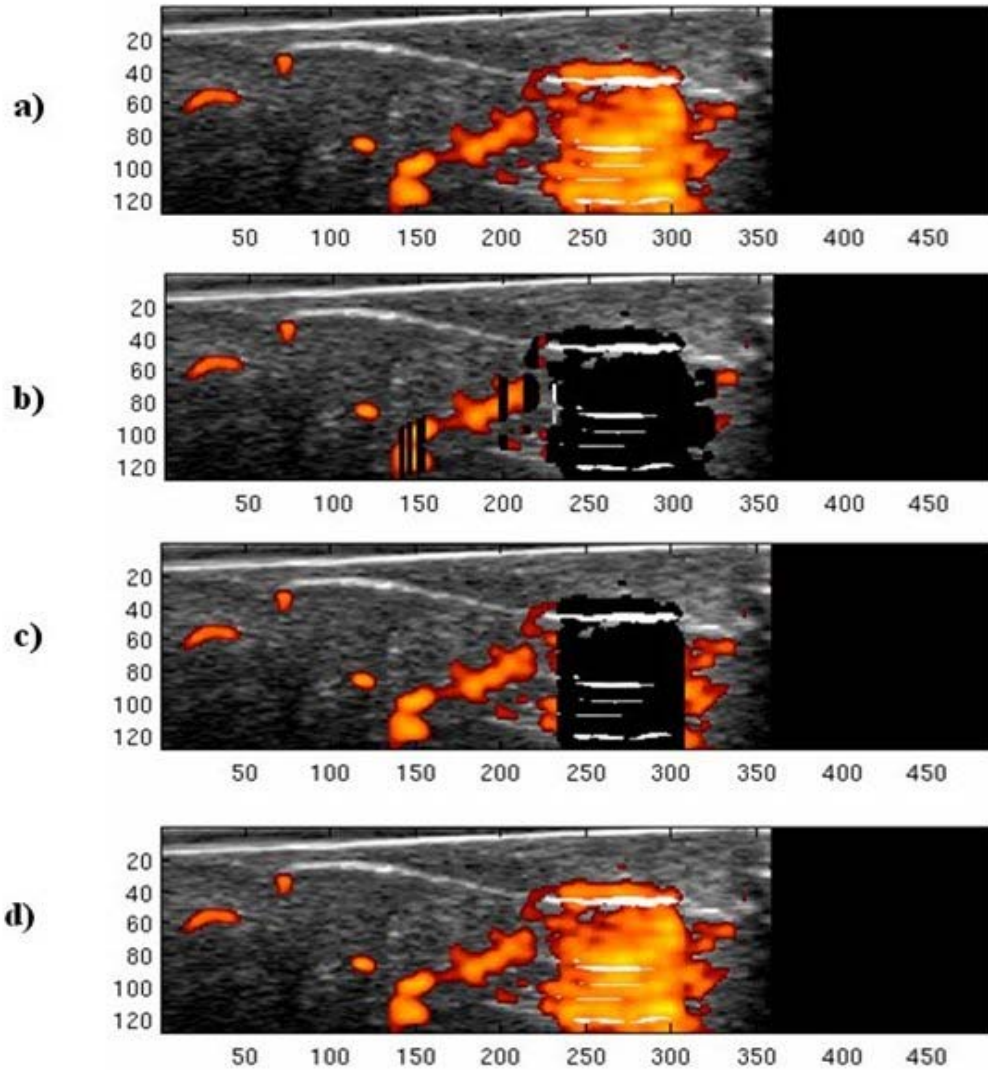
(a) Power Doppler image of finger that contains reverberation artifact (note that the region outside the finger outline was blacked out), b) after passing through an amplitude threshold filter of 25% that reduces both flash artifact and some amount of blood flow, c) after threshold filter of 50% that reduces flash artifact, and d) after threshold filter of 75% that allowed most of the artifacts to pass through. Notice that 50% threshold filter gives the best result.
